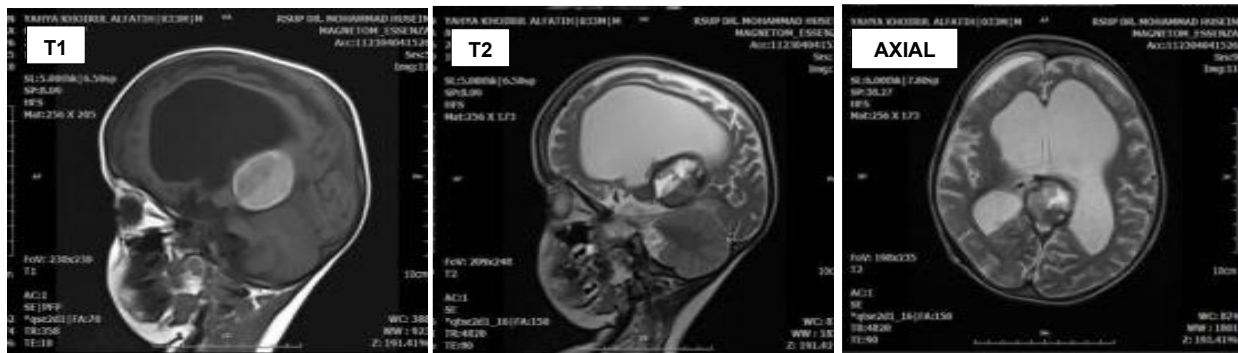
MRI Follow Up 6 months after treatment, showed thrombosis of the vein of Galen, decreased in size.
